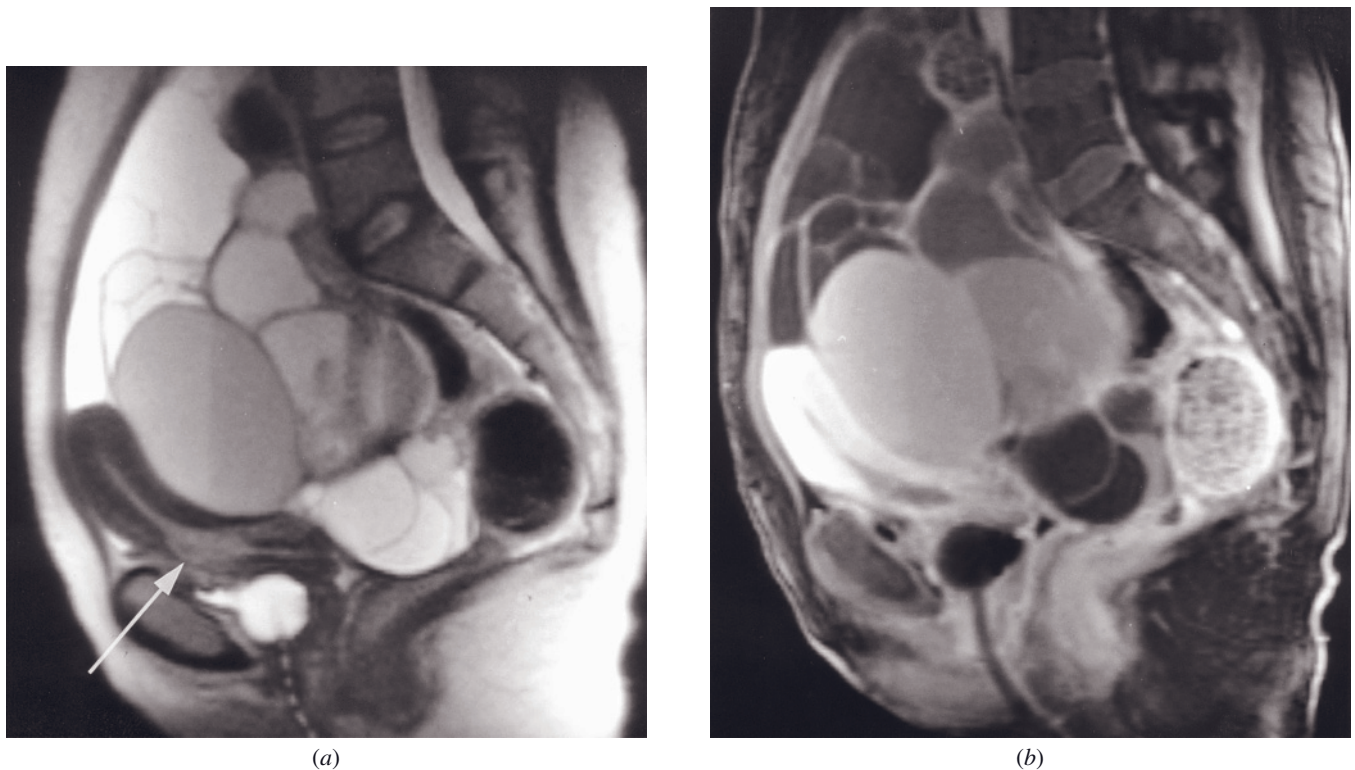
Poorly differentiated adenocarcinoma. Sagittal T2-weighted ETSE (*a*) and gadolinium-enhanced T1-weighted fat-suppressed gradient-echo (*b*) images in a patient with poorly-differentiated ovarian adenocarcinoma and endometrial cancer. A large cystic/solid mass is present in the pelvis, representing ovarian carcinoma. A separate high-signal tumor (arrow, *a*) is appreciated in the lower endometrial canal, consistent with endometrial carcinoma.
